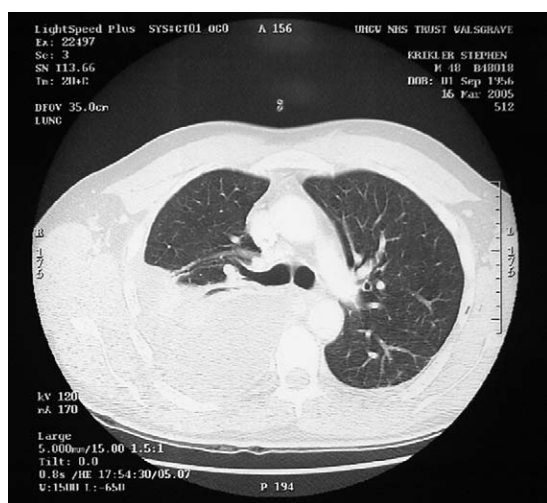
CT at 10 days showing empyema.
